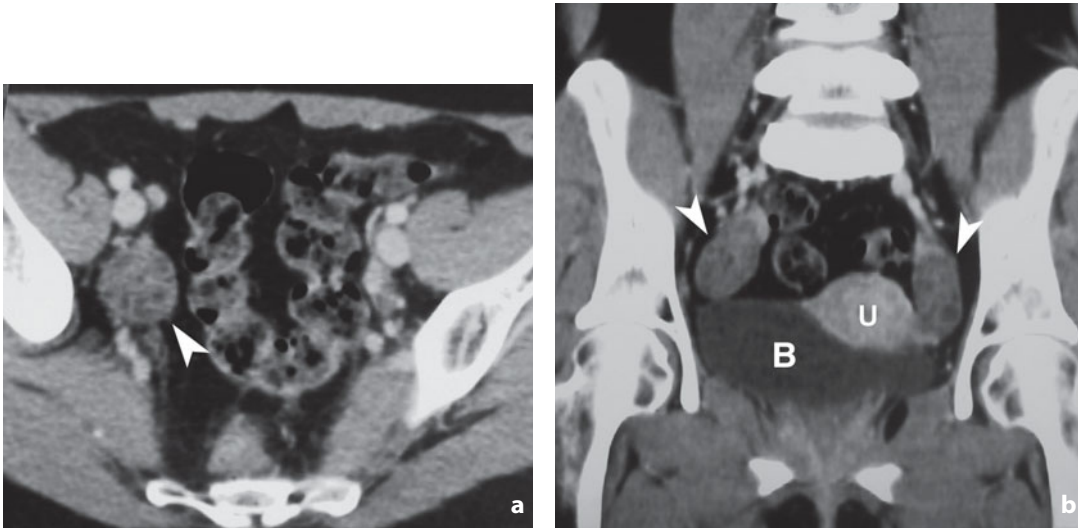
Computed tomography. Normal anatomy of the ovary. a Axial scan. Several small follicles are identifiable in the right ovary (*arrowhead*). b Coronal reconstruction. Both of the ovaries are appreciable (*arrowheads*) with several follicles. *B*, urinary bladder; *U*, uterus
